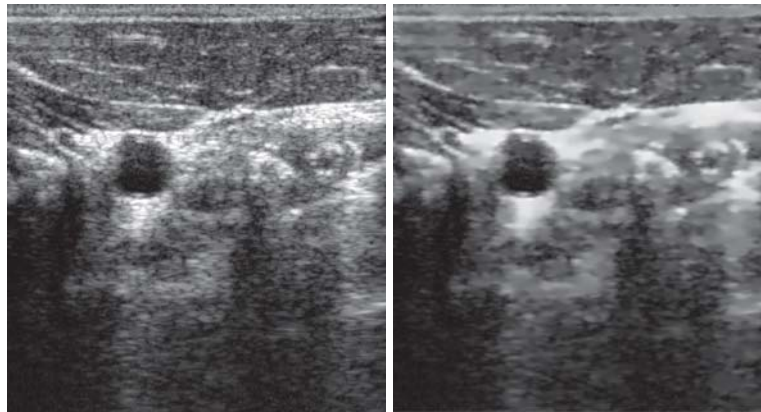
An example for ultrasound speckle removal using anisotropic diffusion filtering [2] (right) shows suppressed speckle and noise while the main image structures are preserved. In contrast to this, the raw input image (left) shows significant noise and speckle across the image.
